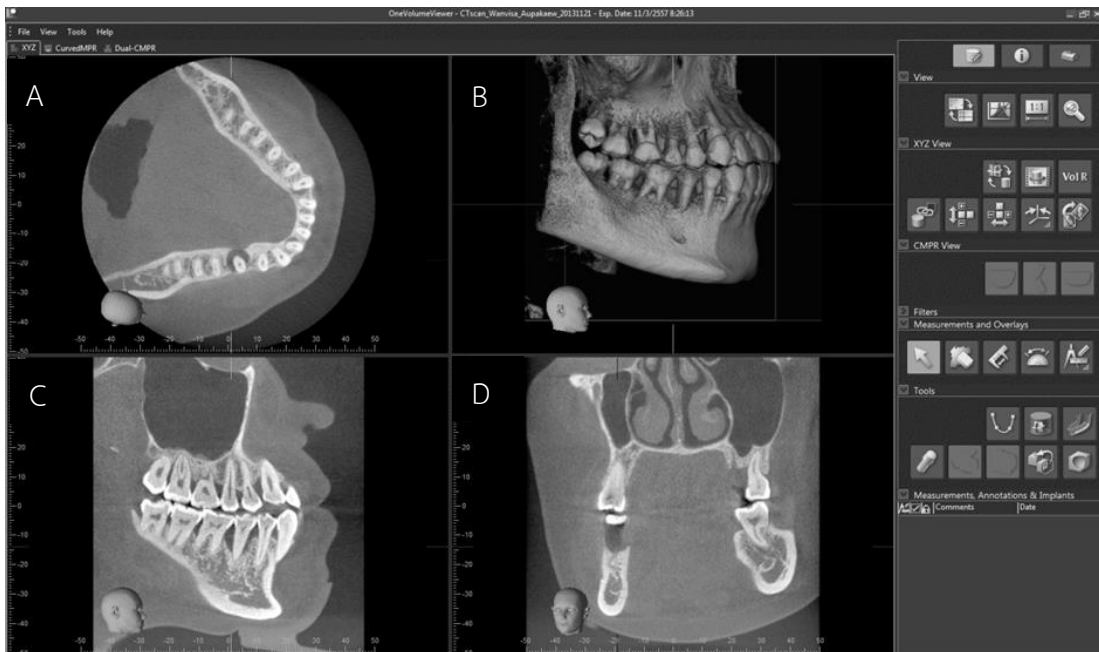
A Screen capture of the CBCT images (A) axial (B) 3D (C) sagittal and (D) coronal view.
